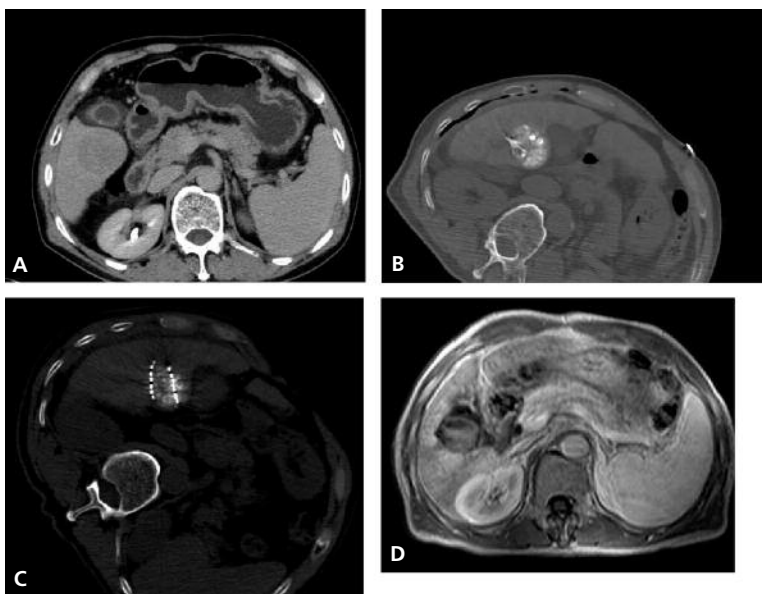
(A-D) A, 2011.1. CT right liver low-density mass. B, 2011.2. RF ablation was given 1 month after TACE treatment. C, 2011.3. Due to mass being close to envelop, ablation is not complete, radionics implantation. D, 2013.09 liver MRI review, complete lesions necrosis
